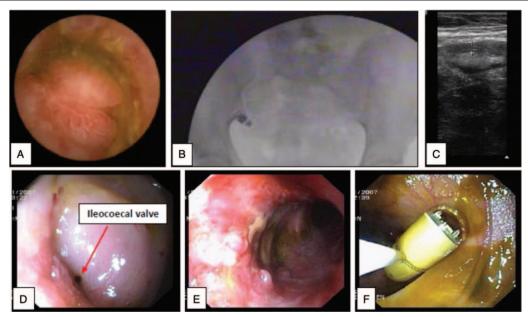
Capsule retention and endoscopic recovery. (A) Capsule image of the lesions in Crohn disease affecting the terminal ileum/ileocoecal valve, (B) X-ray depicting the capsule within the ileal region, (C) ultrasound image with visualization of thickened ileal wall, (D) prominent ileocoecal valve with small opening to the terminal ileum, (E) endoscopic image of the terminal ileum, (F) capsule recovery with polypectomy snare.
